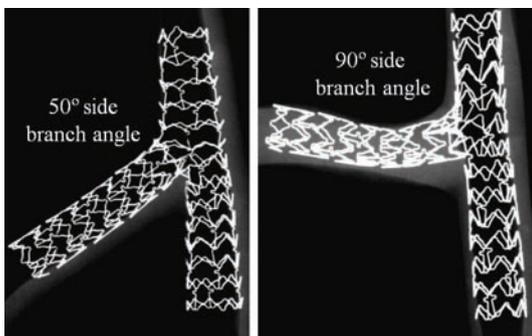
High-intensity Faxitron radiographic images, demonstrating the potential for side branch (SB) ostial coverage of the Xience SBA system. Additional SB stent deployments are shown for SB angles of 50° and 90° (Abbott Vascular, Redwood City, CA).
